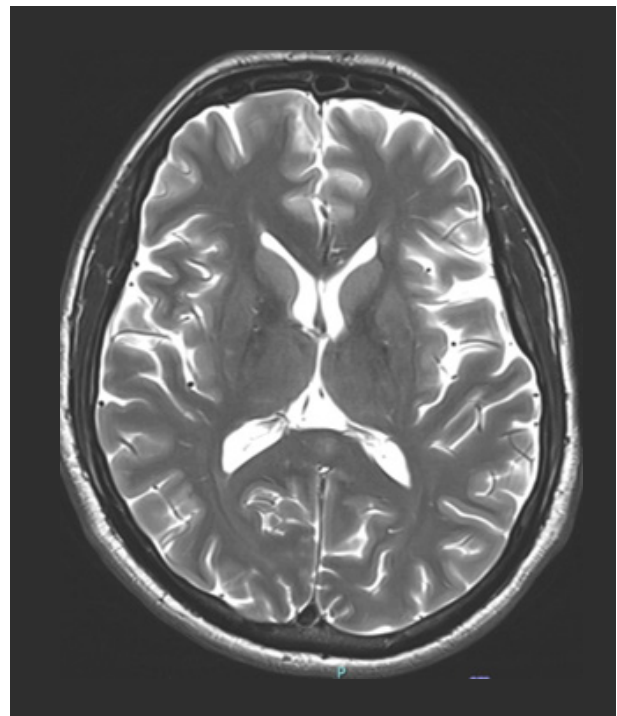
T2-weighted imaging
